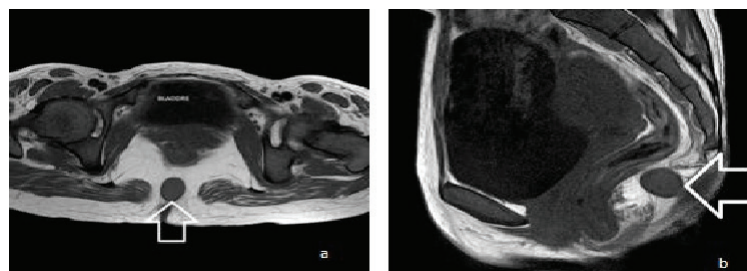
Magnetic resonance imaging pelvis region T1WI. (a) Axial section shows a well-defined hypointense lesion on the posterior aspect of the rectum (white arrow). (b) Sagittal section shows the location of the lesion as presacral (white horizontal arrow).
